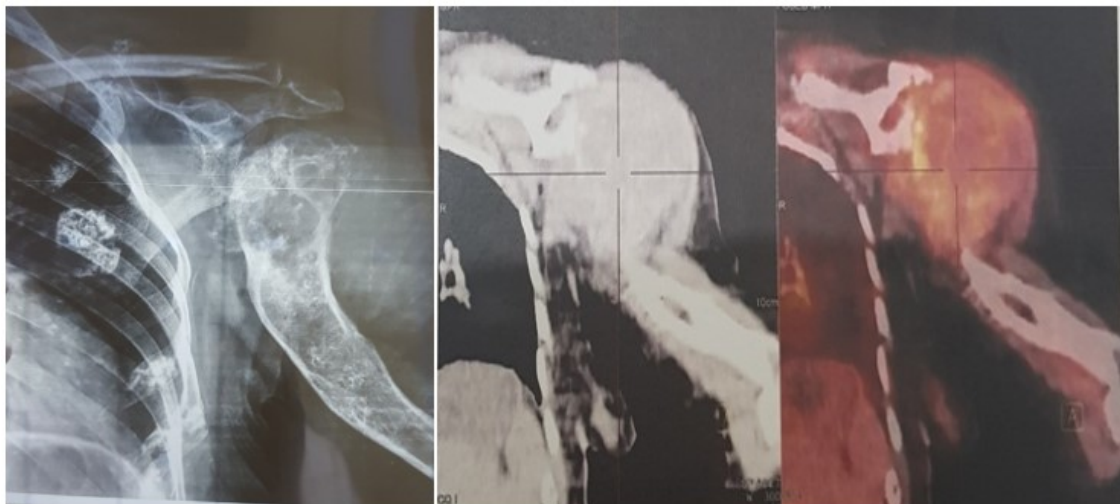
2a: X-rays showing a blown appearance of the cortical humerus with cortical lysis. Figure 2b: PET CT showing a large mass of the hypermetabolic shoulder destroying the humeral head extending outwards towards the muscular and skin planes.
